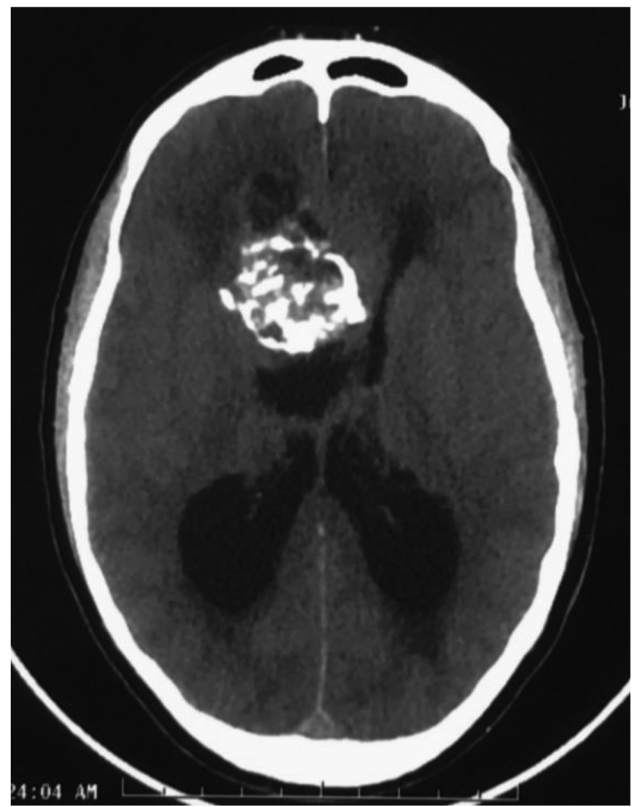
Non-contrast computed tomography revealing a calcified cystic structure in the suprasellar region, accompanied by hydrocephalus.
